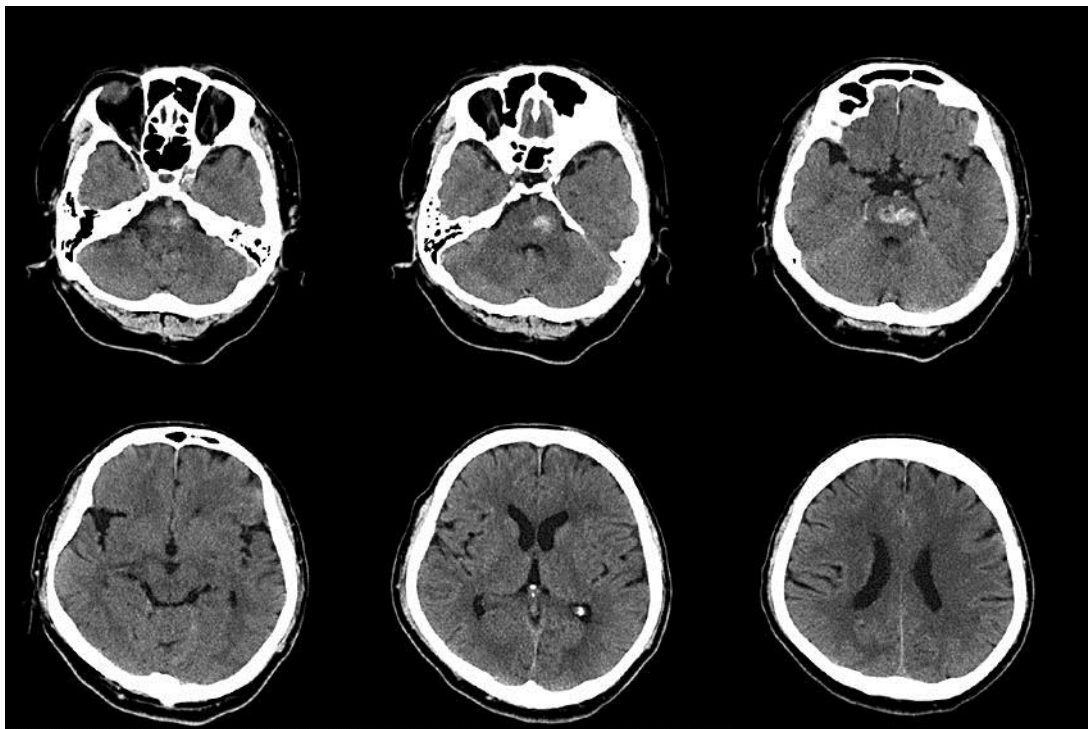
CT on stroke onset. CT revealed hematomas across the pons on both sides but no obvious lesions in the cerebellum and cerebrum.
